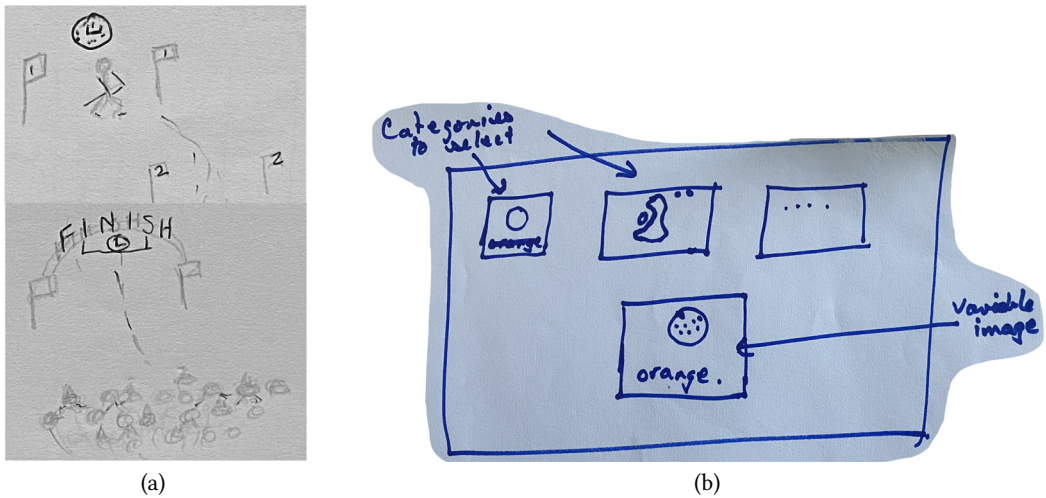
(a) This participant came up with their own ski slalom game. (b) Adapted from the Category Checker CT activity discussed in Section 3.1.2.
